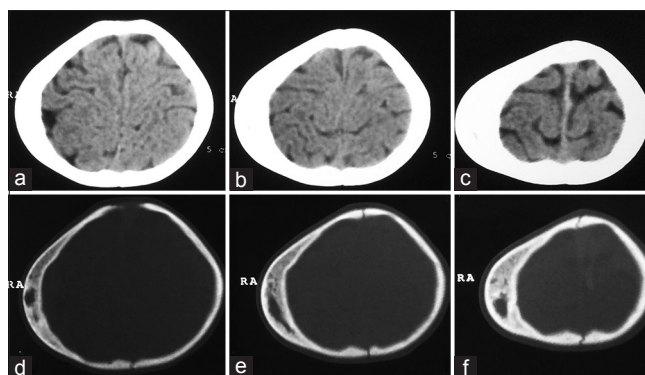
(a-f) Computed tomography scan brain pain with bone window showing a well-defined bone density lesion involving right parietal bone suggestive of ossified cephalhematoma and apparently normal brain parenchyma
